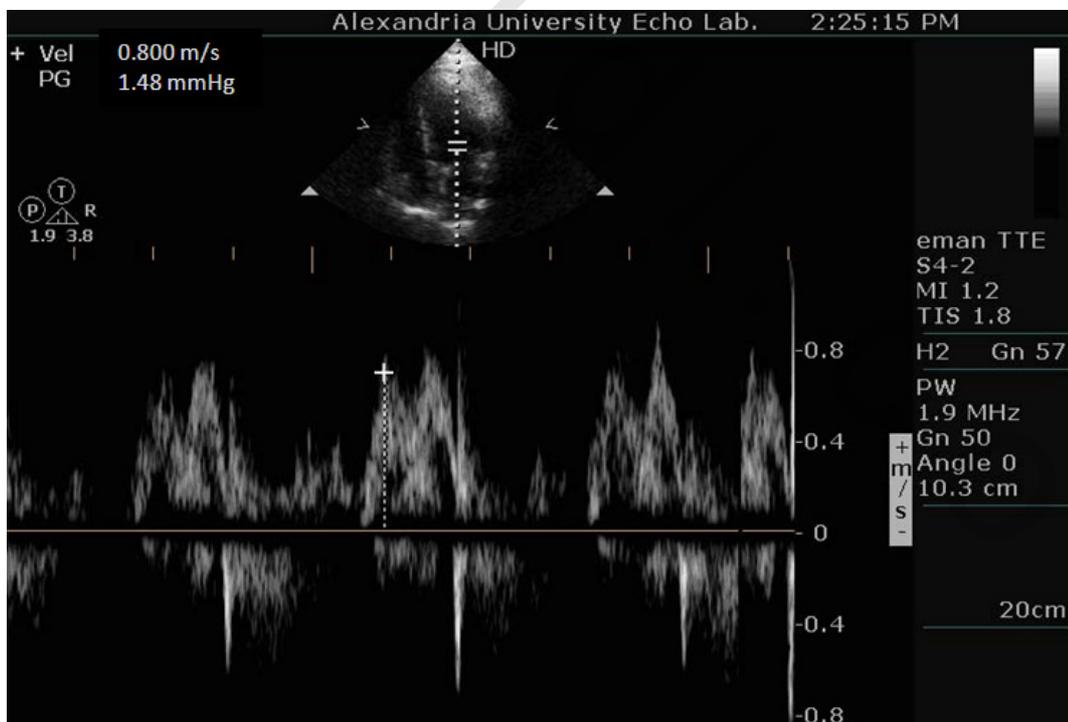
Mitral inflow by pw Doppler before dialysis.
